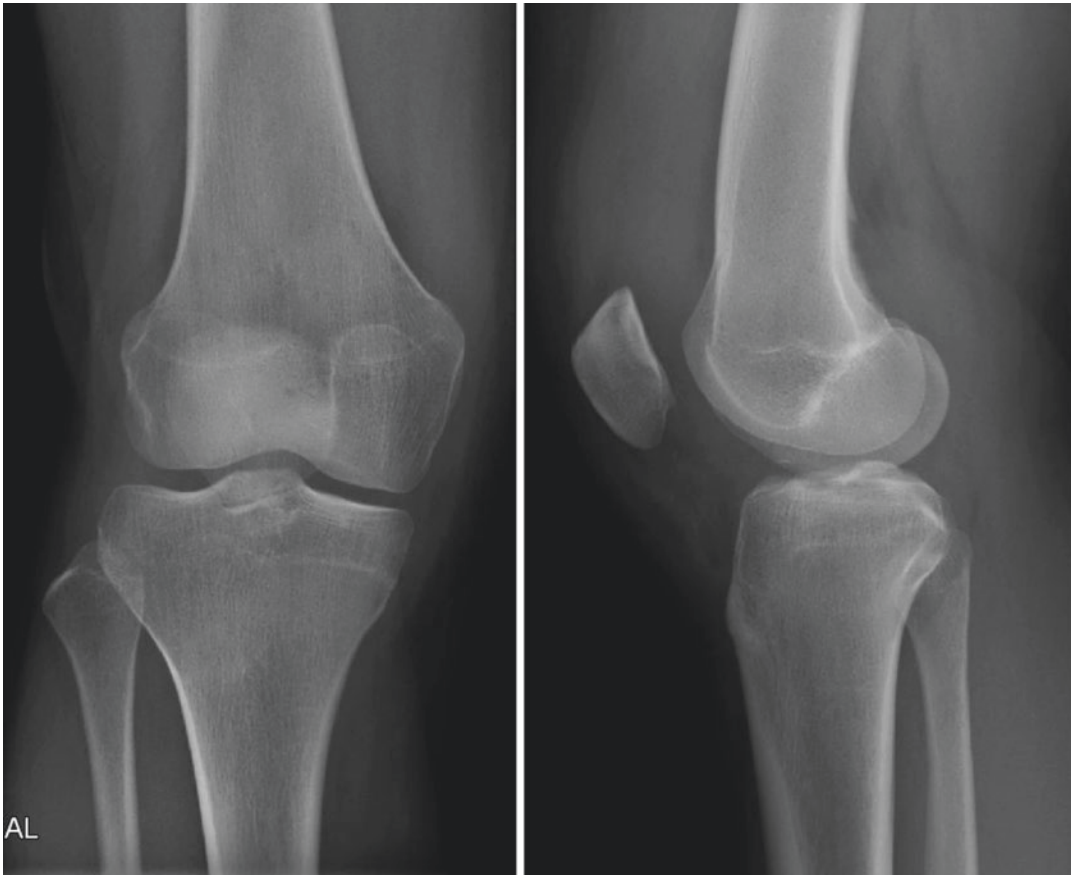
Radiographs at the time of injury
